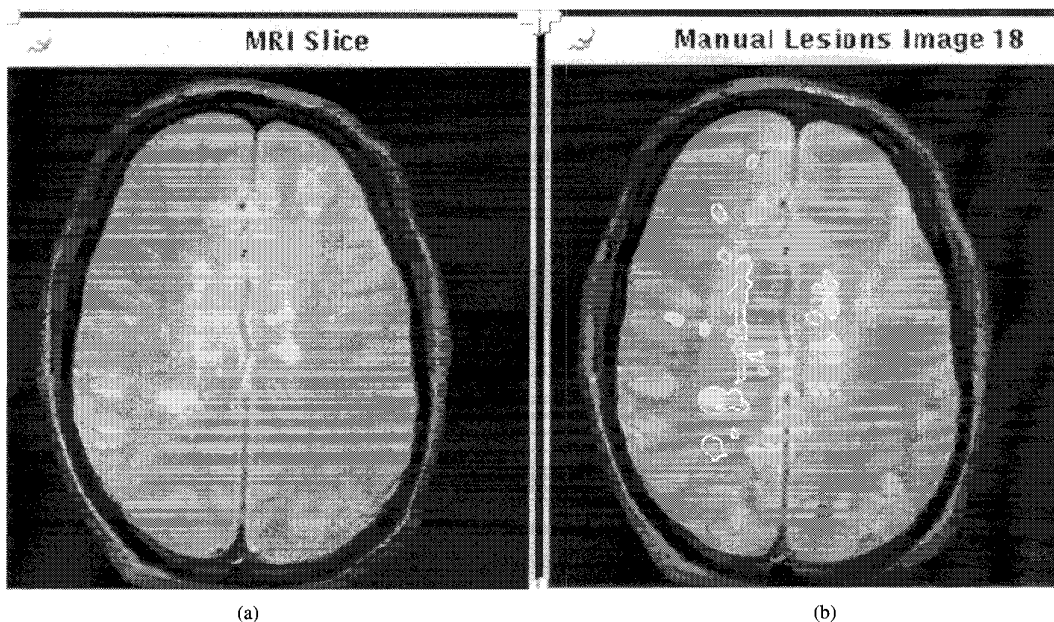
(a) MRI image with (b) MS lesions manually outlined by radiologist.
